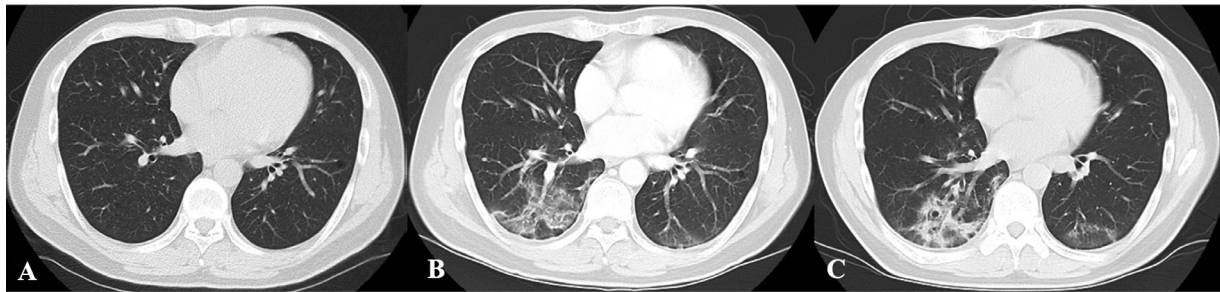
Non-contrast chest computed tomography. Pneumonia was not found on presentation (A) but emerged on the sixth day of hospitalization (B), improved gradually, and finally became scarified (C).
